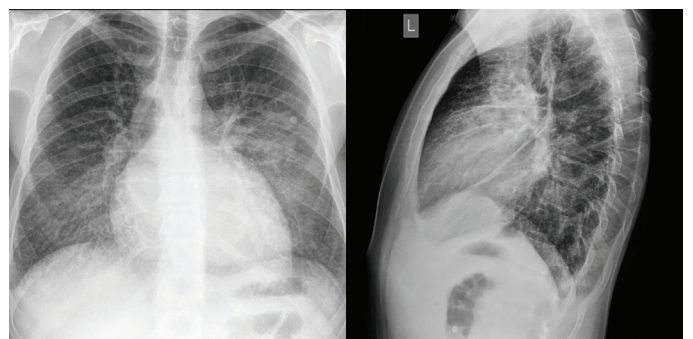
Chest radiograph following thoracentesis
